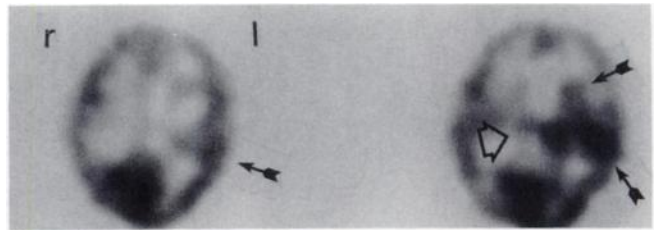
Technetium-99m-HMPAO-SPECT with marked increases of blood flow in different brain regions, most pronounced in the left parieto-temporal regions (small arrows). Note the decreased flow in the cortical regions of both frontal lobes and the asymmetry between the thalami (large arrow).
